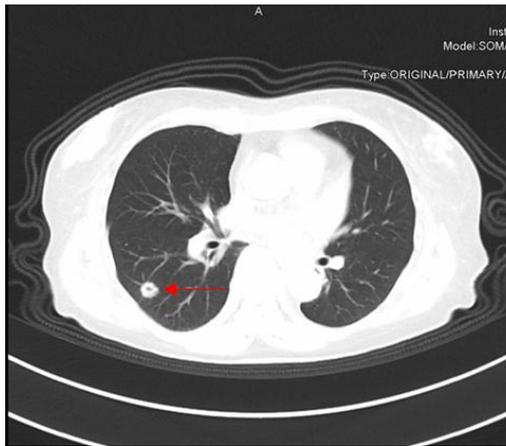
25 months after surgery. CT revealed metastases of bilateral pulmonary (red arrow) and MRI showed a metastasis in the abdominal cavity (white arrow).
